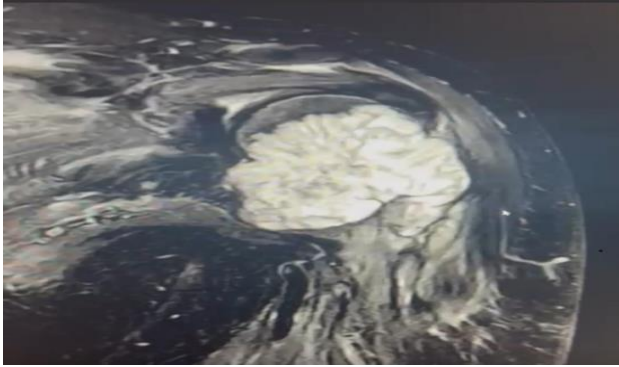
MRI of left humerus of patient B preoperatively showing grossly large aggressive bone tumor heterogeneously enhanced of the proximal humerus with infiltration of the shoulder joint capsule measuring 6.5×6.5×5.7 cm. There are edematous changes of rotator cuff muscles (supraspinatus, infraspinatus, subscapularis), and to a lesser extent deltoid and teres major.
